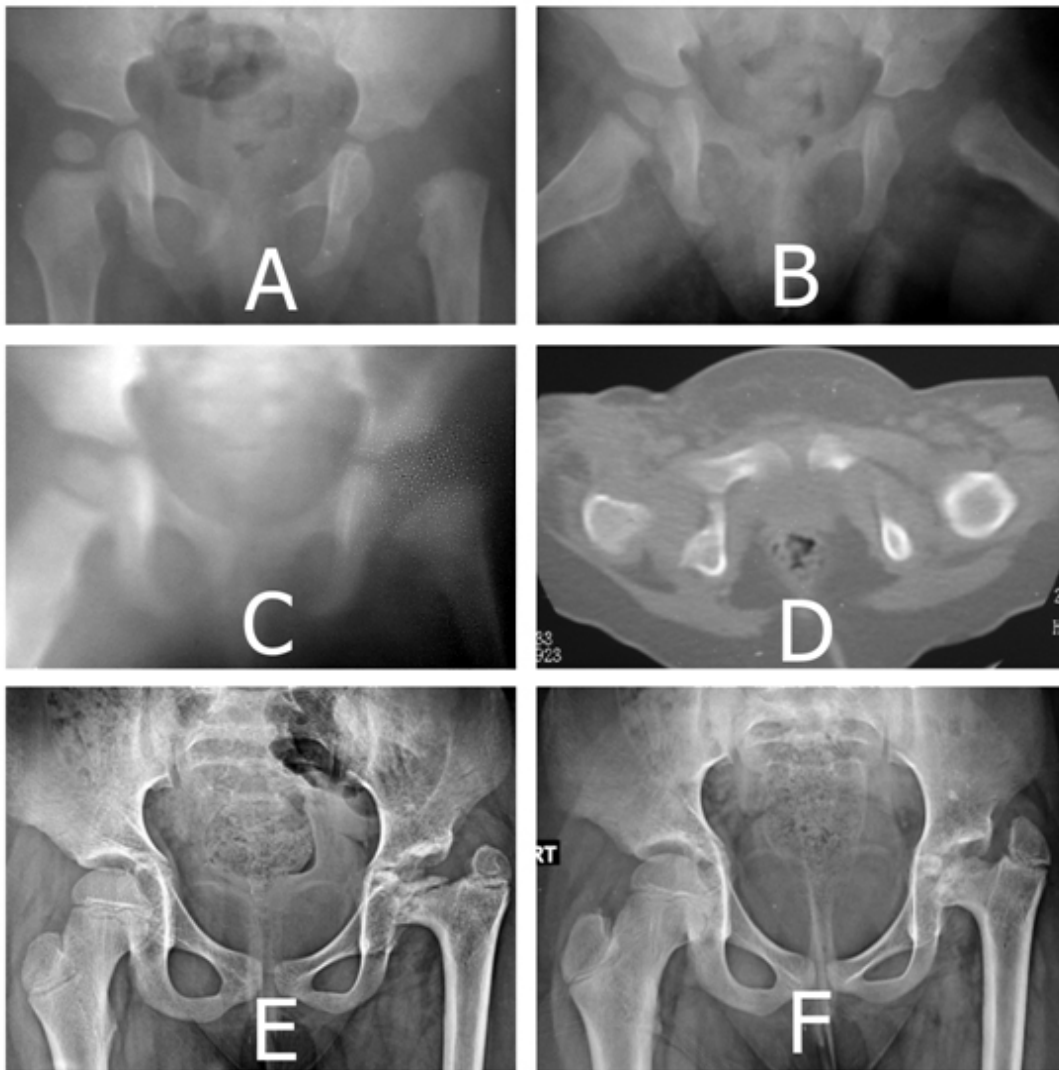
A, girl 2 years old, septic dislocation left hip treated by surgical drainage at age one month, absent upper femoral epiphysis. B, frog-leg lateral view. C, three months after open reduction, restored Shenton line but still absent ossification centre. D, CT shows containment of cartilaginous head within acetabulum. E, 3 years post-operative, flattened upper femoral epiphysis, coxa vara. F, 5 years post-operative, small rounded upper femoral epiphysis, trochanteric overgrowth, coxa vara.
